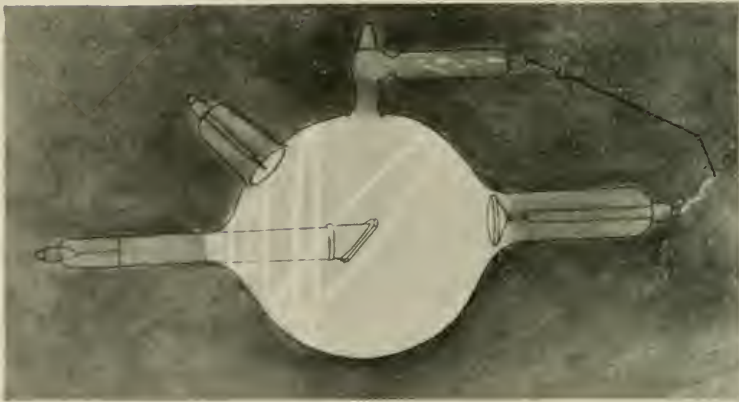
X-ray tube with the current passing through it in the wrong direction.
